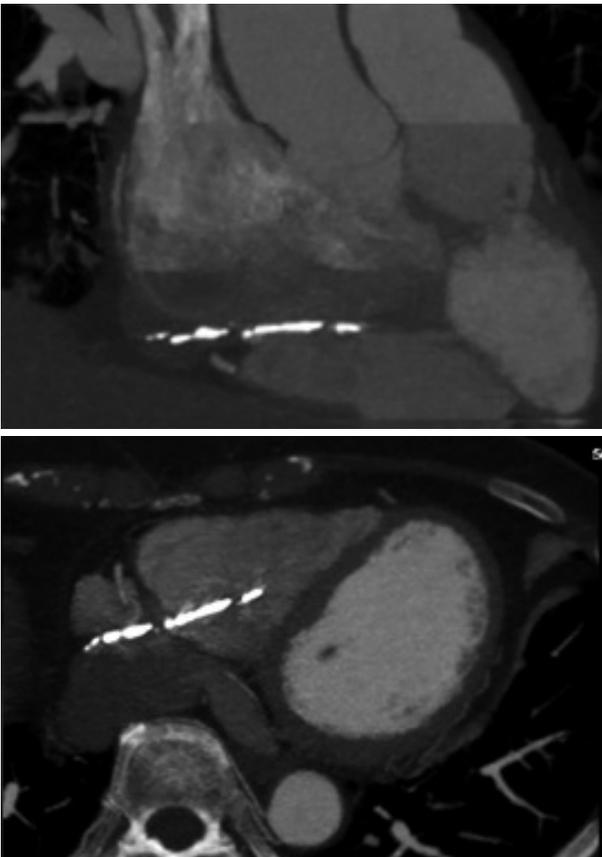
Heart computed tomography revealing an abnormal high density linear structure in right ventricle.
